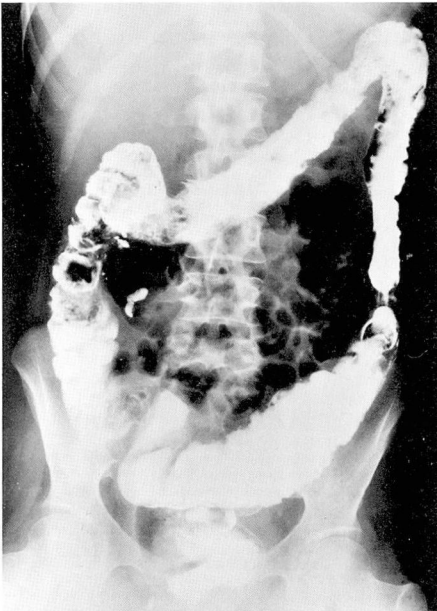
Roentgenogram of the colon after barium enema, March 1965. Loss of haustral markings; ulceration; asymmetrical but diffuse involvement characteristic of transmural (Crohn's) colitis. Note "whiskering" ulceration of transverse colon and narrow distal descending colon.
